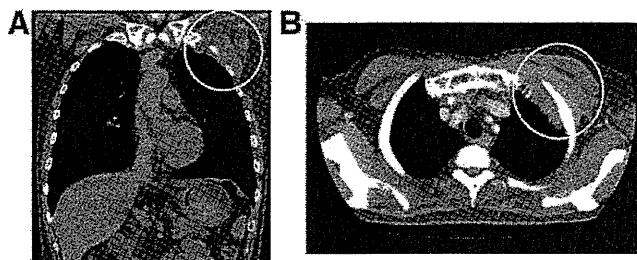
Computed tomographic scan of the chest at the time of diagnosis showing (A) coronal and (B) horizontal views of a tumor on the left anterior chest wall.
